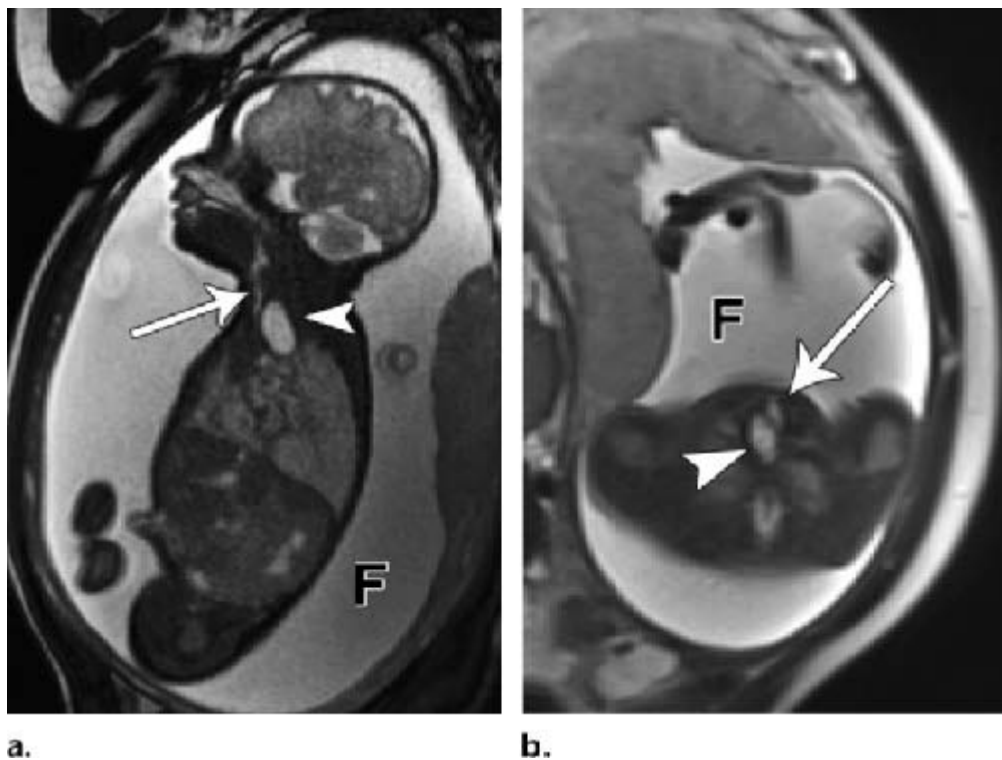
[60] : T2-weighted sagittal sequence through the fetal chest and abdomen (a) and axial T2-weighted sequence (b) show a large esophageal pouch (pouch sign) in the superior thoracic cavity (arrowhead) posterior to the trachea (arrow).
